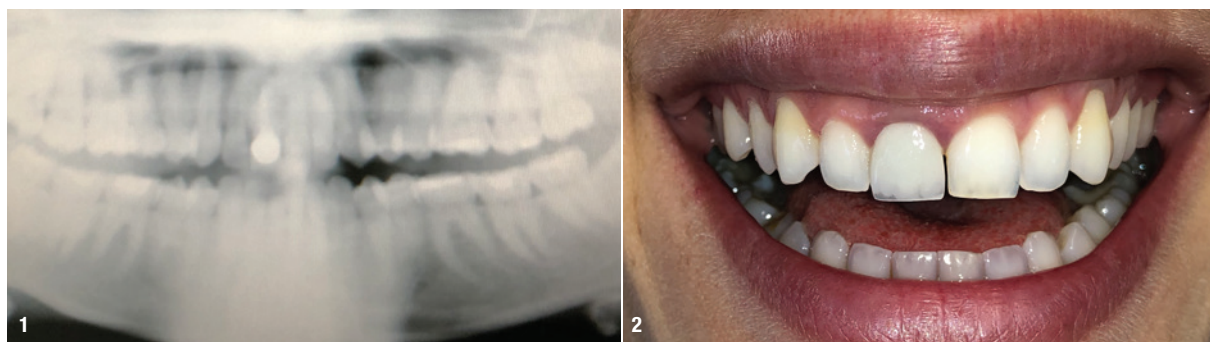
Pre-op radiograph of the patient. Fig. 2: Intra-oral view of the patient before extraction.
